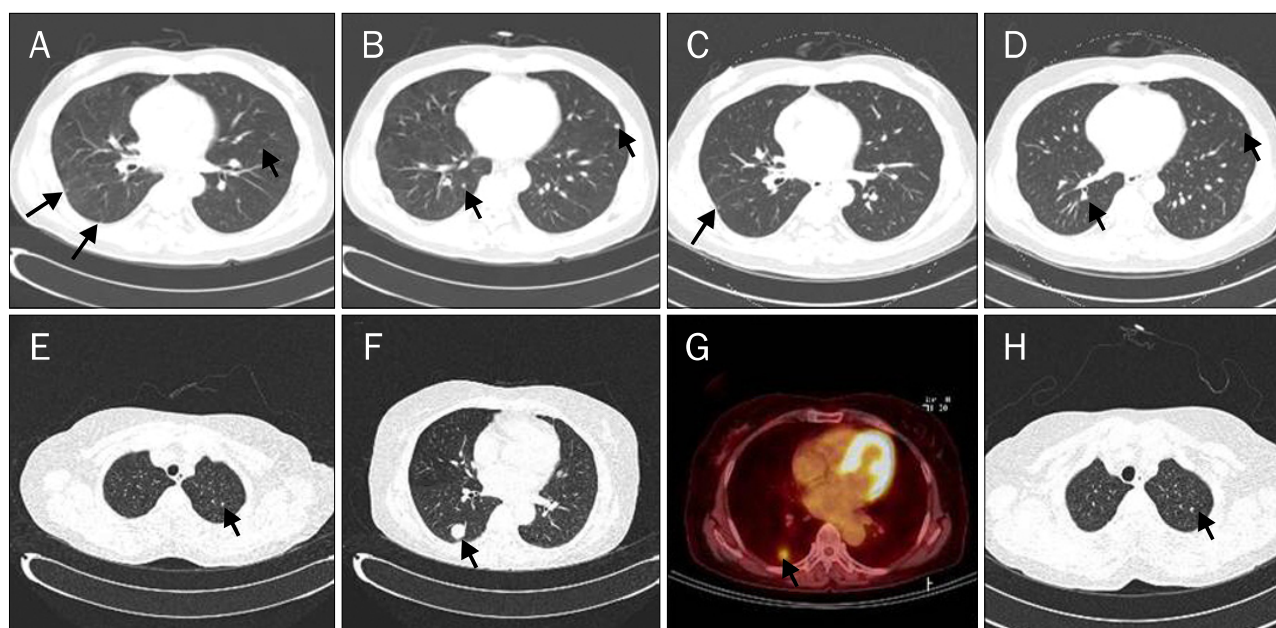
(A-D) The radiologic features of Case 1. (A, B) Chest CT showed multiple lung nodules on both lobes (arrows) before sorafenib treatment. (C, D) Two months after sorafenib administration, chest CT showed that the majority of variable sized multiple nodules on both lungs (arrows) had disappeared and some indeterminate nodules remained. (E-H) The radiologic features of Case 2. Chest CT (E, F) showed a 19 mm sized dense round nodule (arrows) in the right lower lobe (RLL) and a 3 mm sized indeterminate nodule in the left upper lobe (LUL). (G) PET-CT also showed a hypermetabolic nodule (SUVmax 3.4) on RLL (arrow). (H) Two months after sorafenib administration, chest CT showed no interval change of lung nodule in LUL (arrow).
